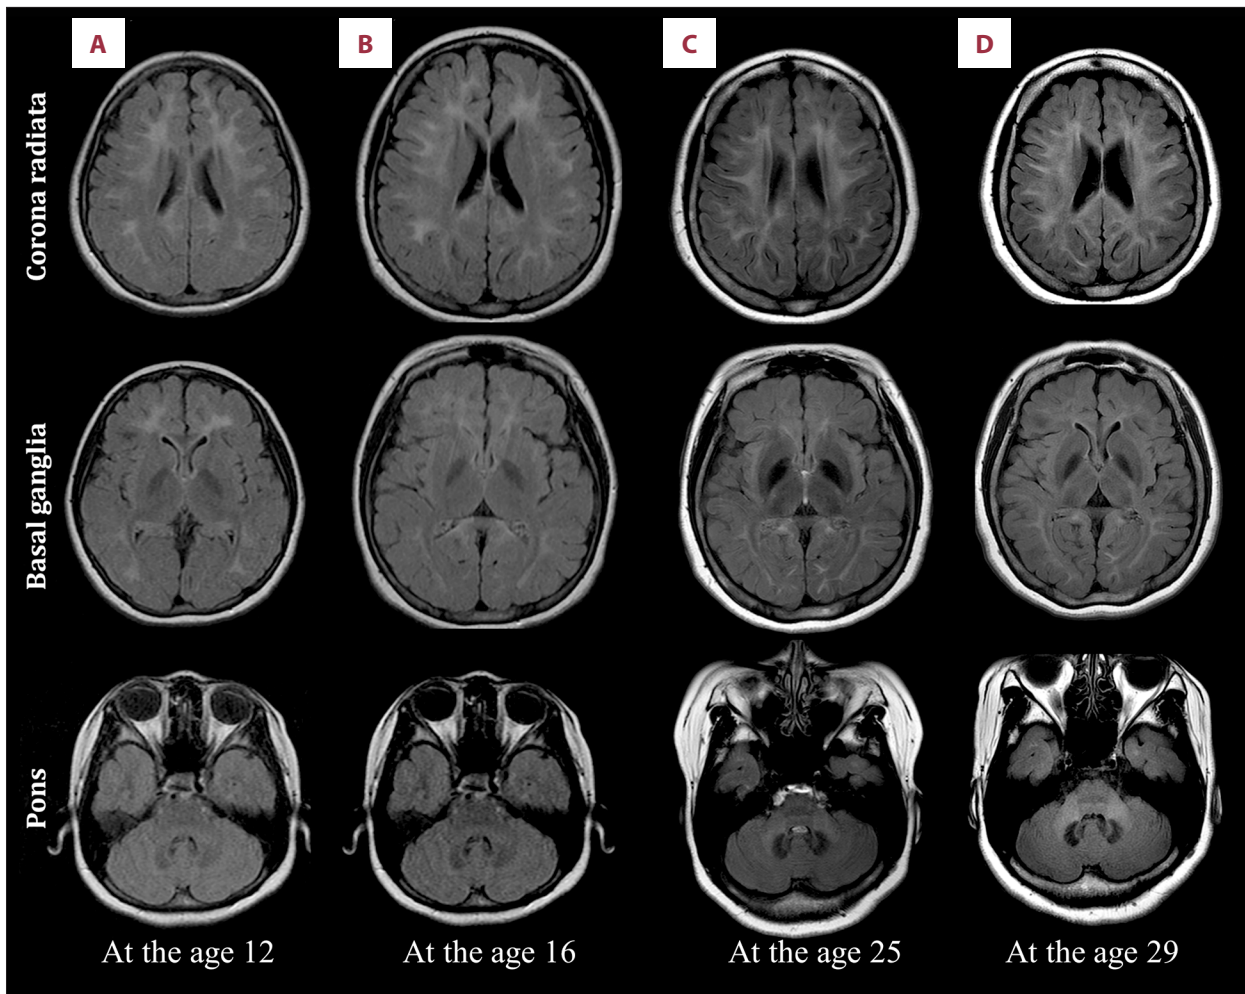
Temporal evolution of VWMD in the patient for 17 years. Serial T2-WI scans of a patient with VWMD. Columns A and B show initial and follow-up MRI images obtained at the ages of 12 and 16 years with symptoms of headache and syncope, respectively. Column C shows images obtained after the onset of motor neurological symptoms, such as hand tremor and upper-extremity weakness, at the age of 25 years, and the column D image was obtained at the age of 29 years due to lower-extremity weakness and severe gait disturbance. Changes in the extent of the lesion over time can be seen at the corona radiata, basal ganglia, and pons levels. In column C, the extent of white matter hyperintensity increased at the corona radiata level, and the invasion of the splenium of the corpus callosum was found. At the level of basal ganglia, there is a distinct dark signal intensity due to iron deposition in the globus pallidus and thalamus. At the level of the pons, dark signal intensity was prominent in the dentate nucleus, and white matter hyperintensity was seen in the cerebellar peduncle in column D.
